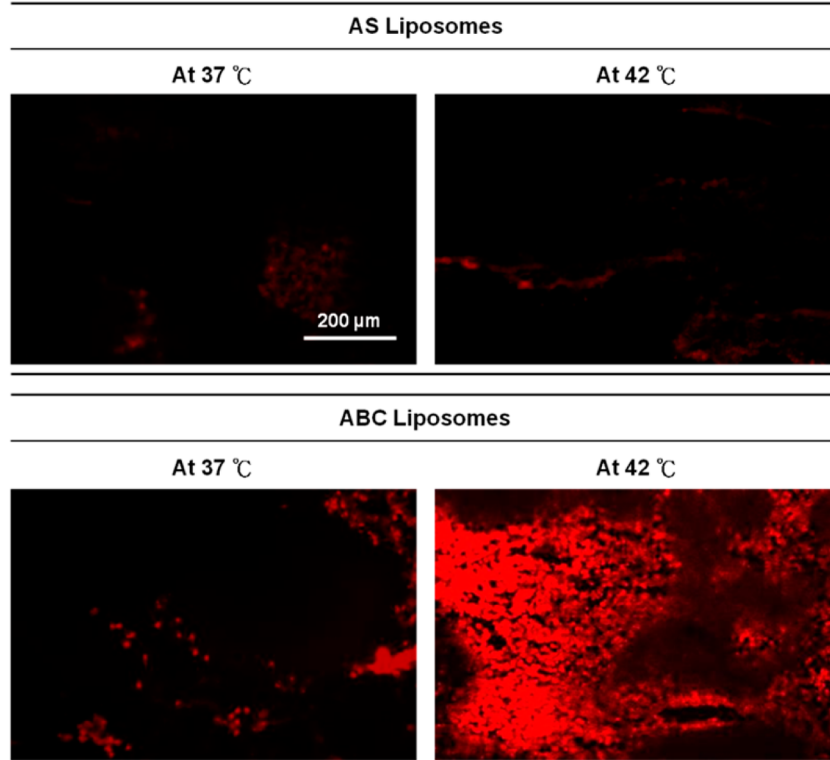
(a) Ultrasound images of the tumors treated with the AS or ABC liposomes at the body (37 °C) and hyperthermic temperatures (42 °C). Area denoted by a square appears at a higher magnification in the inset. HT: hyperthermia treatment. (b) Fluorescent images of DOX of the frozen tumor sections following intratumoral injection of the AS or ABC liposomes at the body (37 °C) and elevated temperatures (42 °C).
